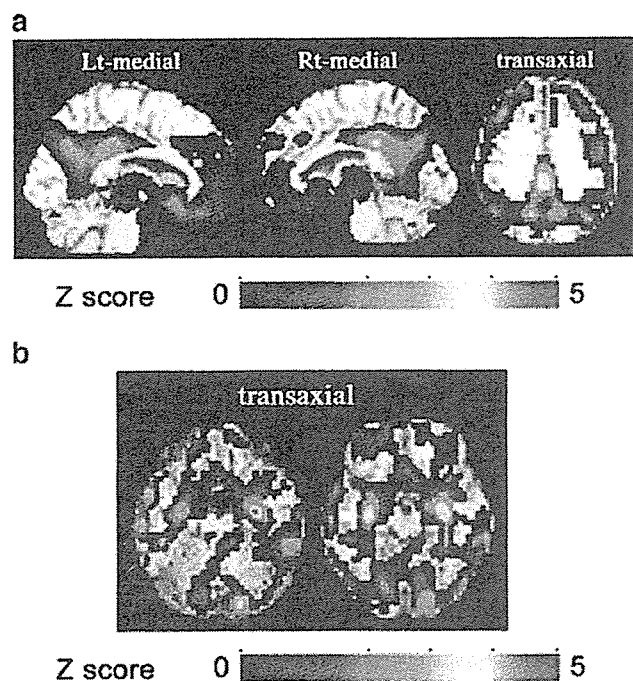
Z score maps of a 67-year-old female with very mild AD (MMSE score=26). a Z score map of FDG-PET. b Z score map of VBM-MRI
